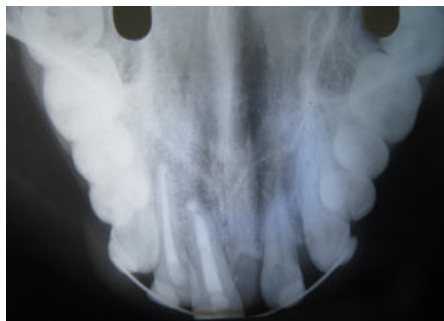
Occlusal radiograph at 6 months follow-up visit showing complete resolution of the lesion and bone formation.
